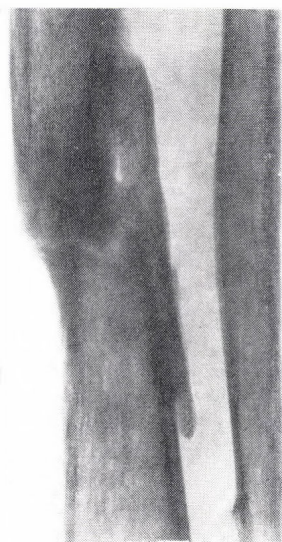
Case in Fig. 2. In the gap of pseudarthrosis and at the sites where the graft was well adapted, the transformation of the callus into bone tissue is fairly visible roentgenographically
